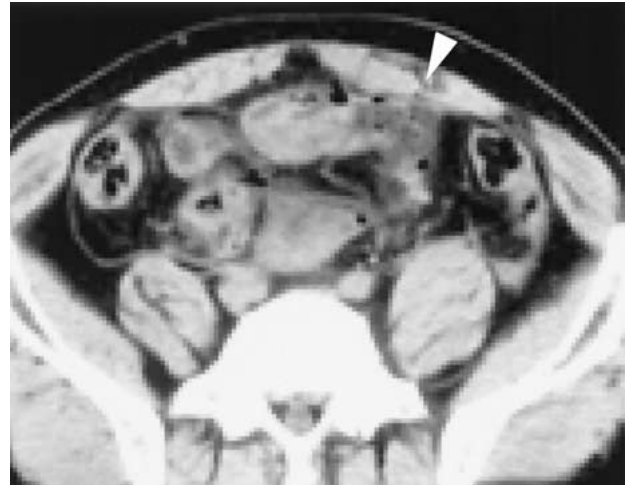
Unenhanced pelvic CT image of an ileal perforation caused by a blunt abdominal trauma. Air bubbles and hazy density in the fat tissue are observed around the perforated ileal loop (*arrowhead*).
